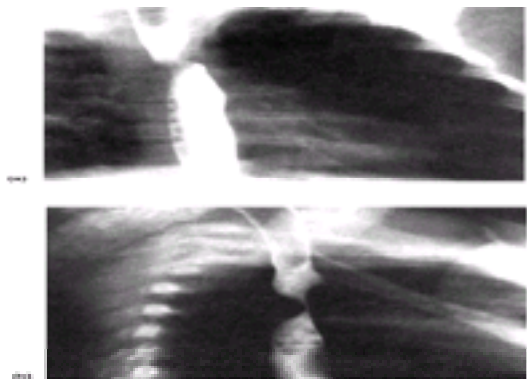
(a) This 6-month-old infant presented with severe stridor. The barium swallow showed marked indentation of the esophagus from a posterior lesion. Near occlusion of the trachea was seen on the lateral radiograph as well. (b) A double aortic arch was suspected on the basis of this study and was confirmed by an echocardiogram. Bronchoscopy immediately prior to repair demonstrated near occlusion of the trachea.
